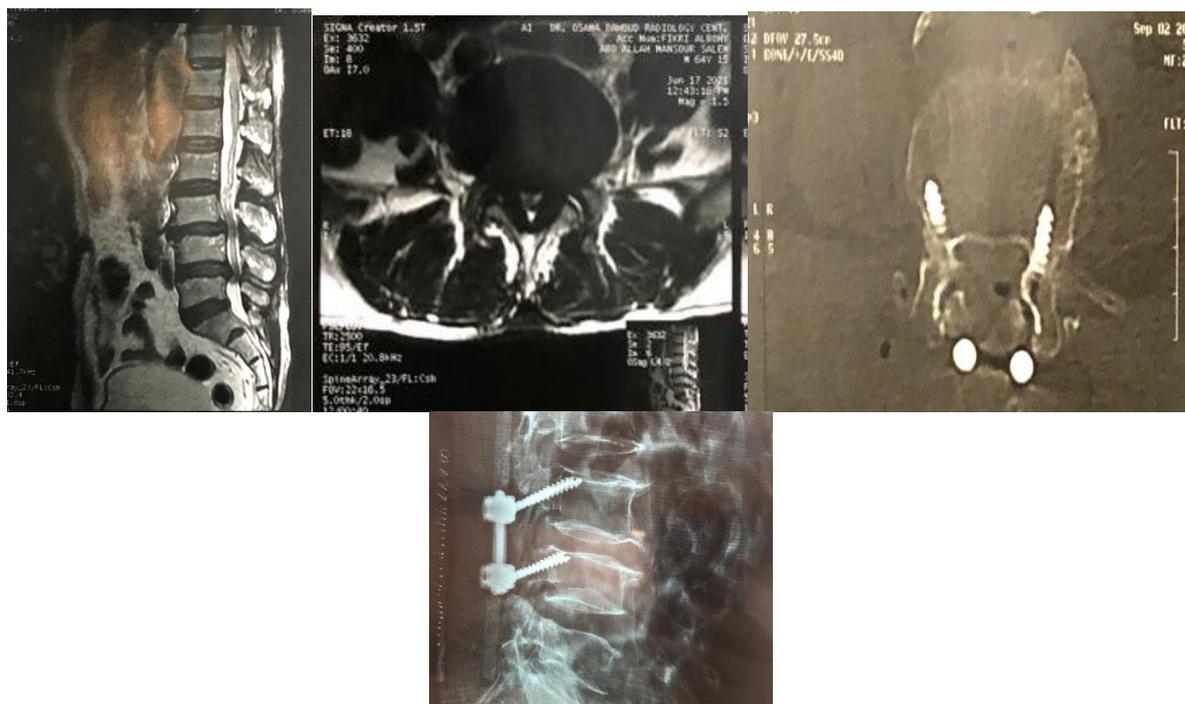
preoperative MRI and postoperative CT scan and plain radiogram of L3-4 fixed by CBT.
